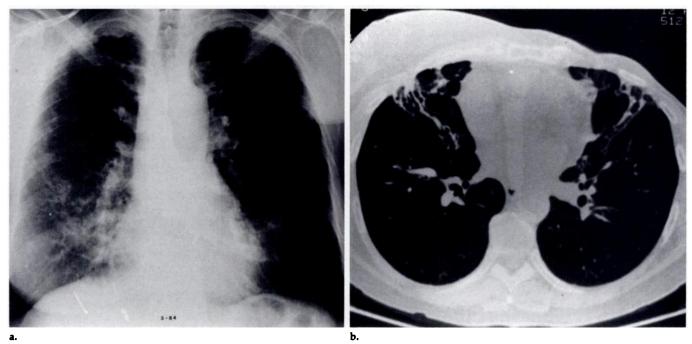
Nonclassical form of disease in an older woman with a diagnosis of chronic bronchitis for several years because of a chronic cough and malaise. Finally, cultures were positive for MAC infection, and the correct diagnosis of NTMB infection was made. (a) Chest radiograph reveals irregular interstitial opacities in the right middle lung and lung bases. (b) CT scan shows bronchiectasis, one of the most common features of nonclassical NTMB infections. The middle lobe and lingula are the most common sites of disease. Irregular alveolar hyperattenuation is also seen in the right middle lobe.
